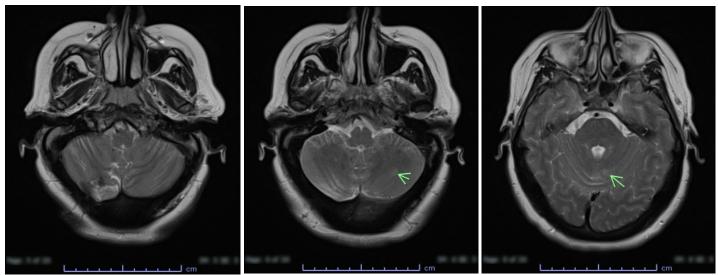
Axial planes of brain MRI from 2016. (a) Postsurgical findings in the right cerebellum after resection of ganglioglioma. Mild FLAIR hyperintensity surrounding the resection cavity is unchanged. (b) Area of T2 hyperintensity within the left cerebellum within the superior cerebellar hemisphere adjacent to the vermis and (c) area of T2 hyperintensity within inferior cerebellar hemisphere, that are unchanged and nonspecific.
